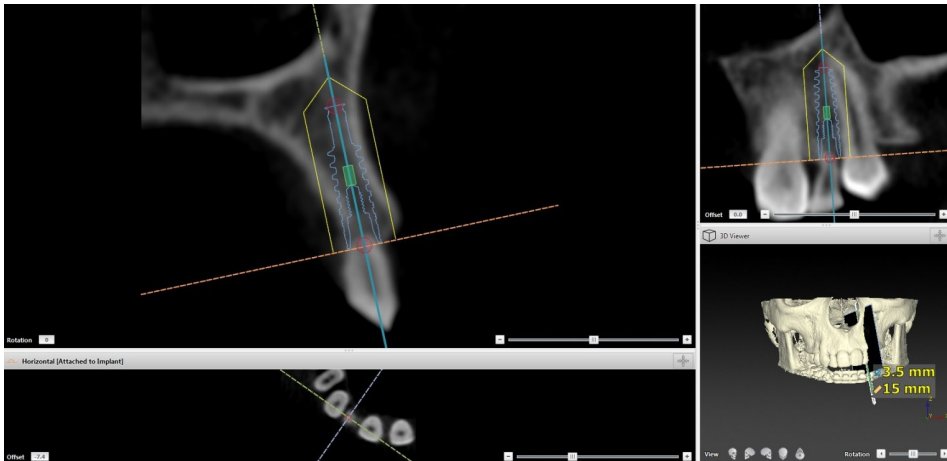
Alignment of planning implant according to the coordinates of the prospective position of the implant in the CBCT image taken at T_{pre} with the failing tooth still in place.
